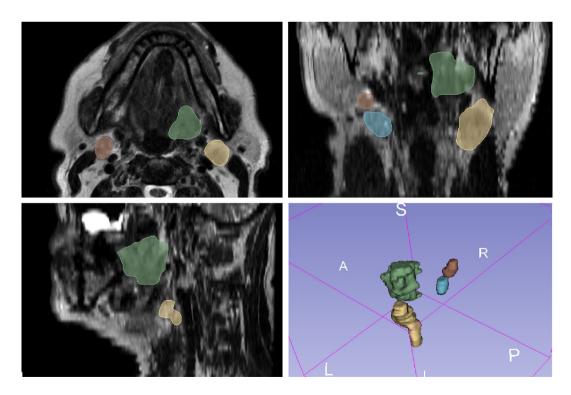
A 52-year-old man affected by an oropharyngeal squamous cell carcinoma of the left palatine tonsil with bilateral metastatic lymph nodes, shown on T2-weighted images in the axial (A), coronal (B), and sagittal (C) plane, with a 3D representation of the user-defined lesion volumes (D). [Color figure can be viewed at wileyonlinelibrary.com]
